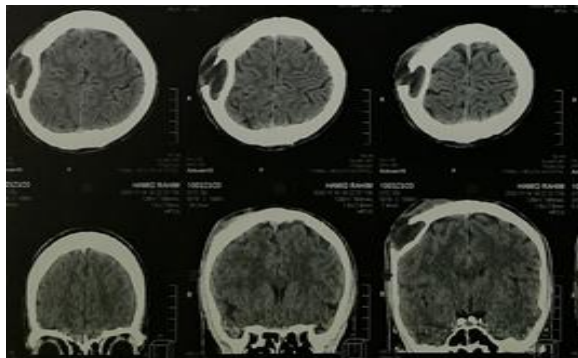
CT brain (axial view), showing intradiploic hypodense lesion with lesion in right parietal bone.
